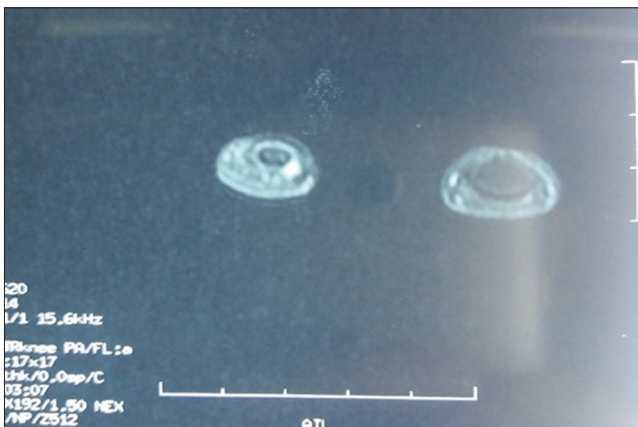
MRI of the hand showing a nodular hypersignal image
